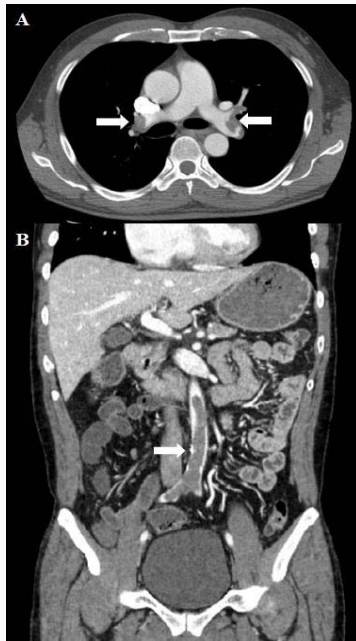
Preoperative computed tomography. (A) Bilateral pulmonary thromboembolism, (arrows) (B) Abdominal aorta and bilateral common iliac artery thrombotic occlusion, (arrow).
